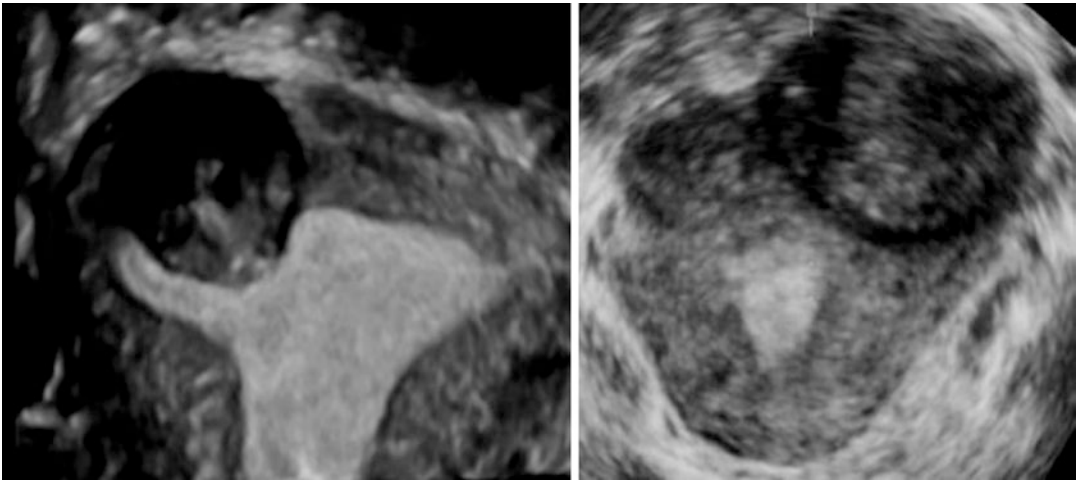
Ultrasound images of fibroids
